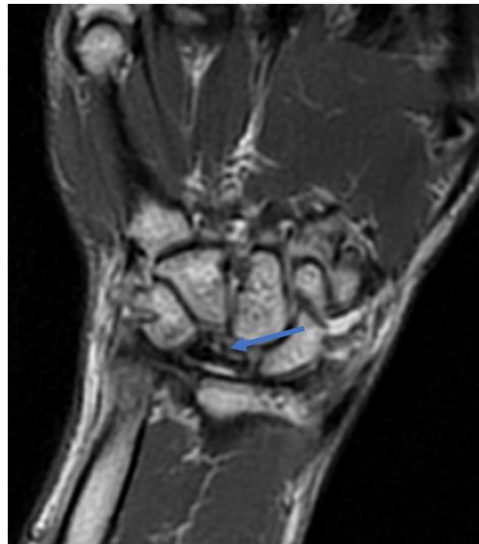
Coronal T2-weighted MRI showing a heterogeneous signal within the lunate (blue arrow)
